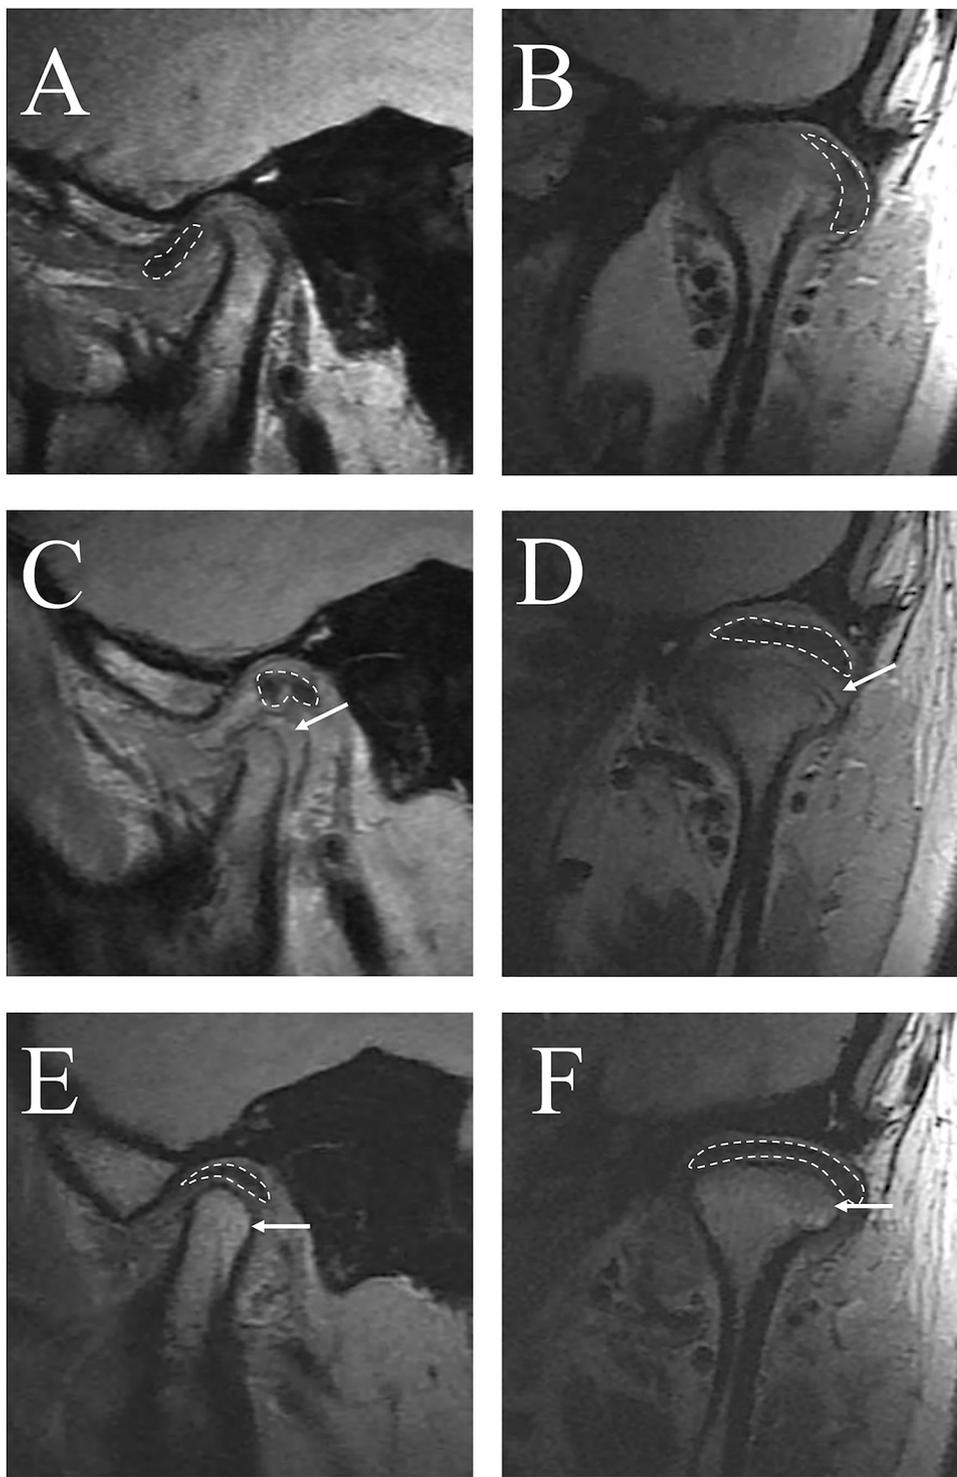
MRI of the TMJ before surgery (A: coronal view; B: sagittal view), 6 months after surgery (C: coronal view; D: sagittal view), and at 24 months after surgery (E: coronal view; F: sagittal view) in the same patient, showing successful disc recapture and new bone formation of condylar remodelling. The white dotted line defines the TMJ disc; the white arrows mark the new bone formation.
